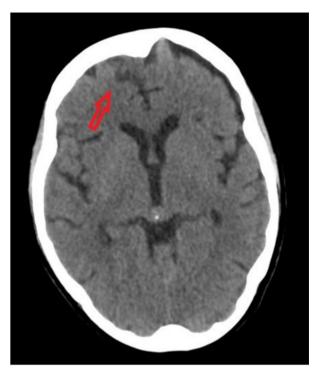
A direct brain computed tomography scan section showing the isodense right dural parafalcine nodular lesion (dimensions: 0.9×1.6 cm).
